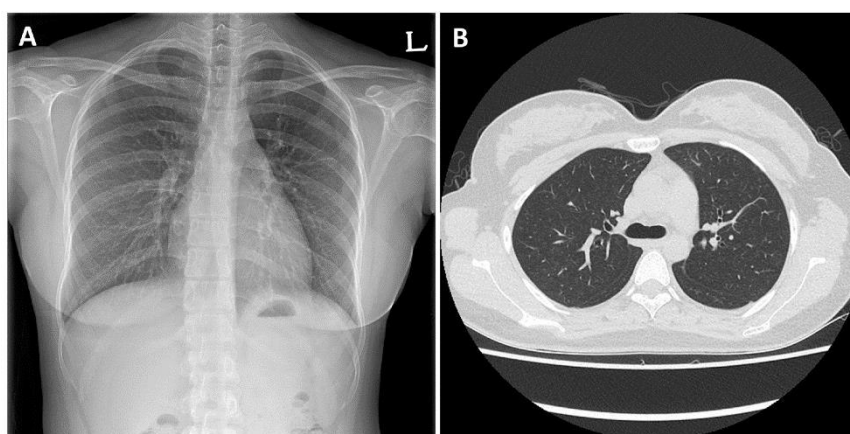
A Chest X-ray (A) and CT scan (B) of a patient with persistent eosinophilic pneumonia²³
